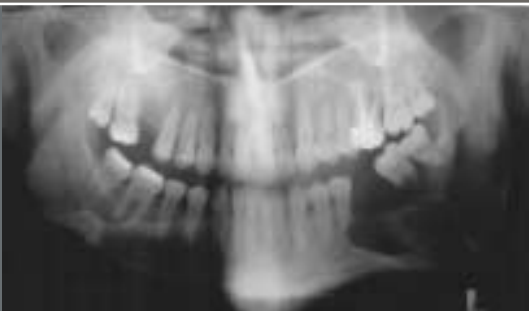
Preoperative radiography of patient.
